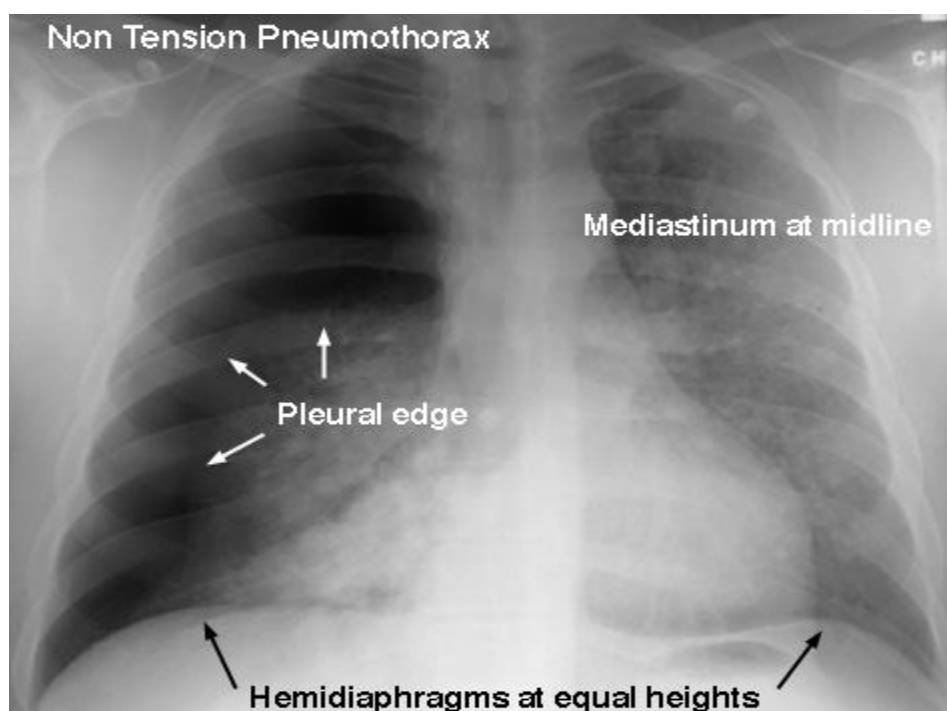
Chest x-ray (PA view) showing non-tension pneumothorax on the right side
